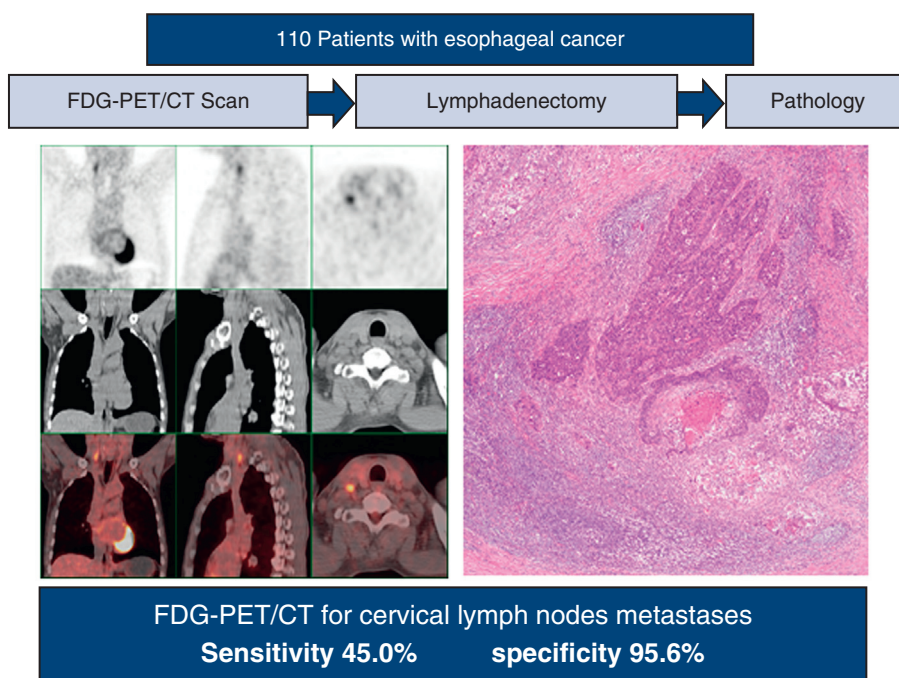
FDG-PET/CT in diagnosing cervical lymph nodes metastases of esophageal cancer. FDG-PET/CT, Fluorodeoxyglucose-positron emission tomography/computed tomography.
